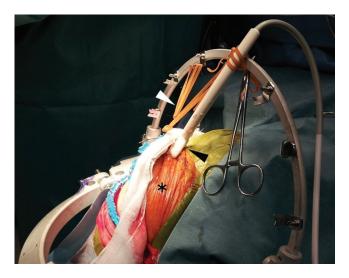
Setup for monitoring the venous outflow from the sinus pericranii. A hockey stick probe for color Doppler ultrasonography (*black arrowhead*) was fixed to a Sugita head frame and positioned on the left superior eyelid. The skin flap (*asterisk*) was retracted with scalp hooks (*white arrowhead*).
